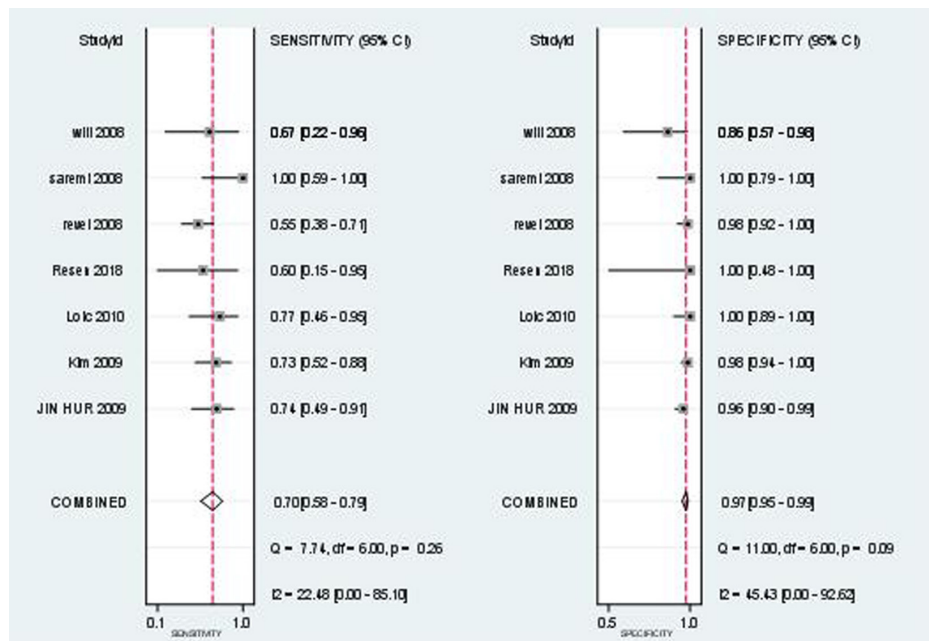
Sensitivity and specificity of CT for PFO diagnosis: PFO sensitivity 0.70 [95% CI: 0.58,0.79], specificity 0.97 [95% CI: 0.95,0.99], sensitivity heterogeneity  $I^2 = 22.48$ , specificity heterogeneity  $I^2 = 45.43$ .
